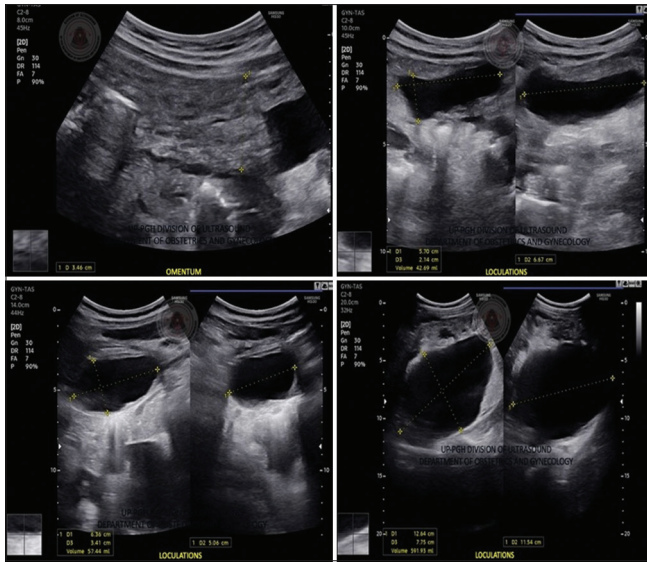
Transvaginal ultrasound. Omentum are variably thickened with non-uniform cystic spaces. Multiple loculations within the abdominopelvic cavity consistent with pseudomyxoma peritonei
